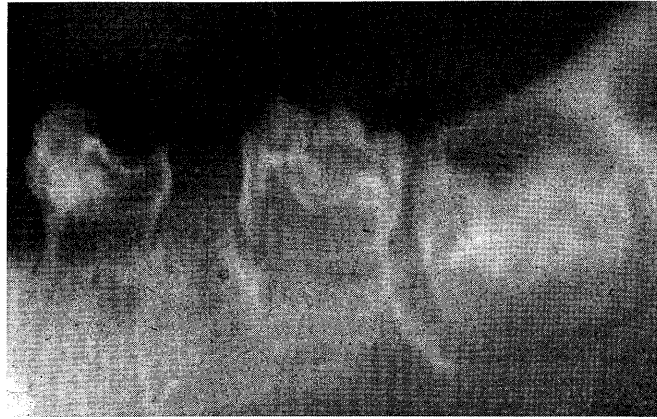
Periapical x-ray at the age of 2 years and 8 months demonstrating the characteristic "ghost-like" appearance of the mandibular left primary molars and first molar.
